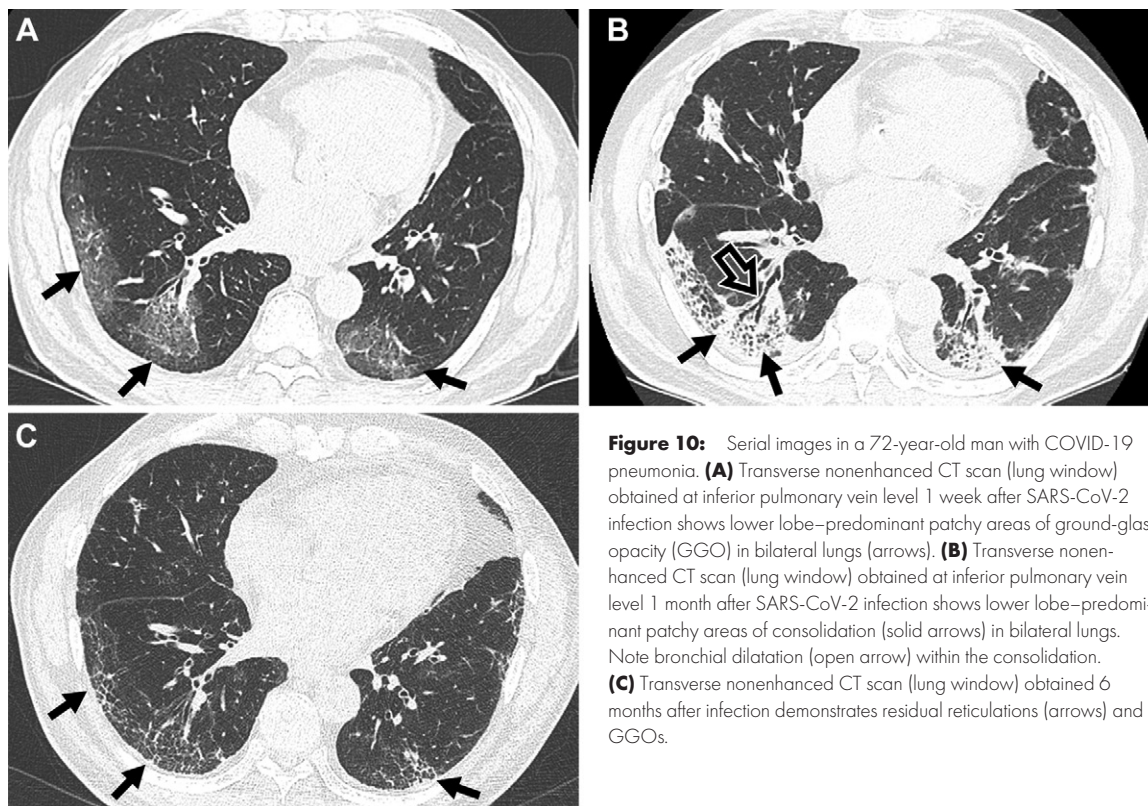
Serial images in a 72-year-old man with COVID-19 pneumonia. (A) Transverse nonenhanced CT scan (lung window) obtained at inferior pulmonary vein level 1 week after SARS-CoV-2 infection shows lower lobe–predominant patchy areas of ground-glass opacity (GGO) in bilateral lungs (arrows). (B) Transverse nonenhanced CT scan (lung window) obtained at inferior pulmonary vein level 1 month after SARS-CoV-2 infection shows lower lobe–predominant patchy areas of consolidation (solid arrows) in bilateral lungs. Note bronchial dilatation (open arrow) within the consolidation. (C) Transverse nonenhanced CT scan (lung window) obtained 6 months after infection demonstrates residual reticulations (arrows) and GGOs.
